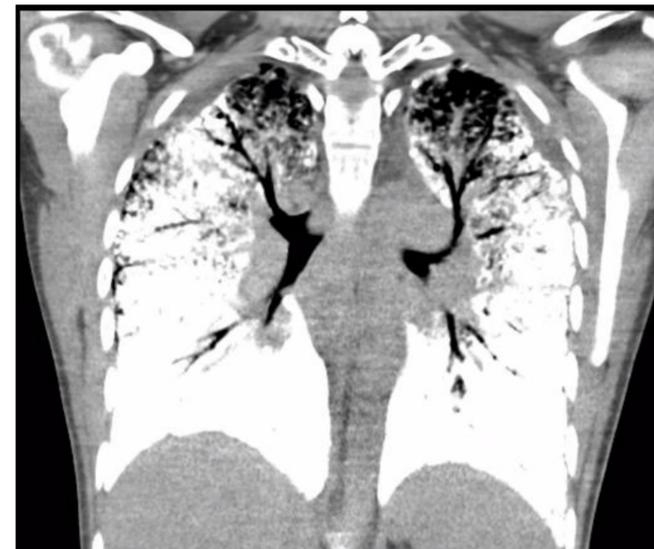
High Resolution Chest CT Coronal View
